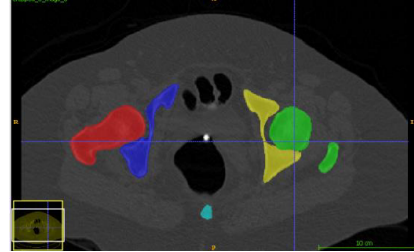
Axial Slice of a CT Scan with all ROIs.
